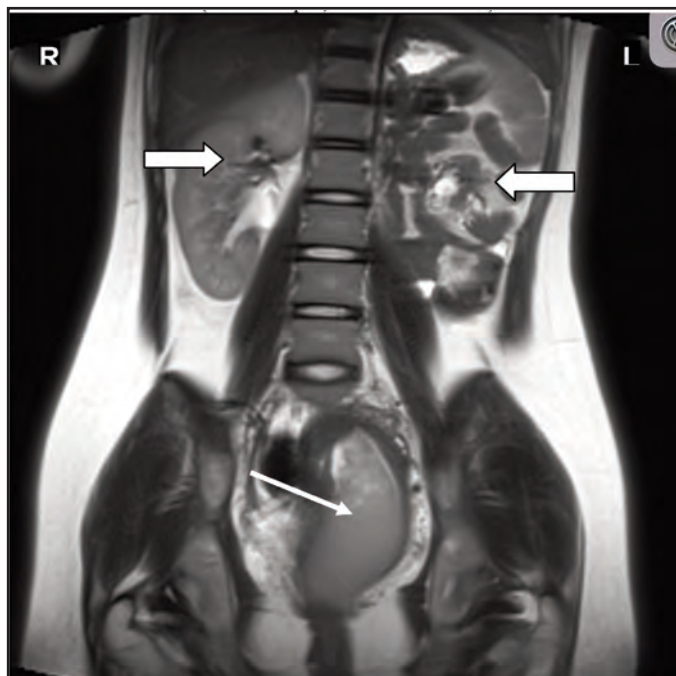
Coronal T2WI MRI shows dilatation of left hemivagina filled with blood (thin arrows), normal right kidney and absence of left kidney (thick arrows)
